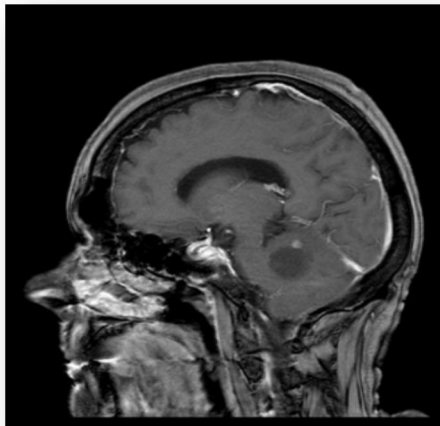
Initial contrasted sagittal MRI
